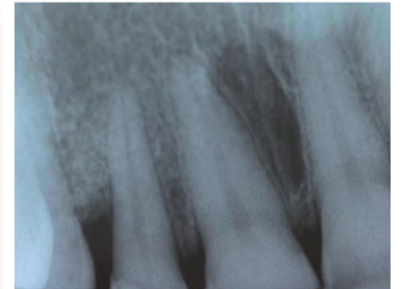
Radiographic after 6 months.
